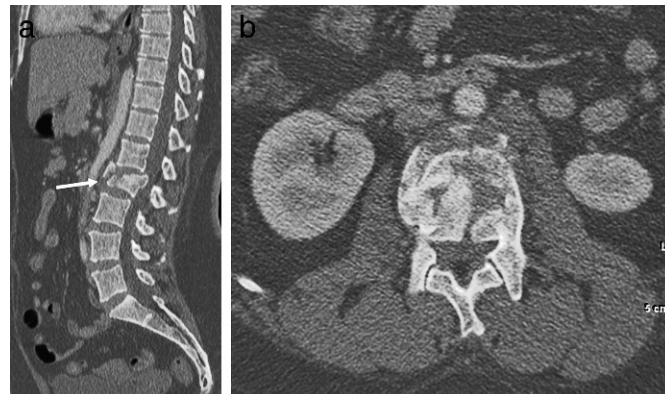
Burst fracture. (a) Sagittal CT demonstrates a burst fracture of the L2 vertebral body (arrow) with retropulsion of fracture fragments into the spinal canal. (b) Axial CT at the level of the burst fracture.
